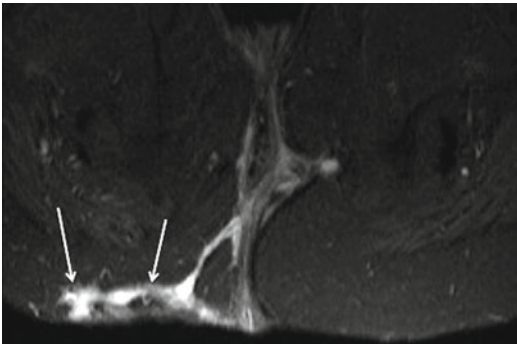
Axial STIR MRI in a patient with extensions (*arrows*) into the right buttock, several cm from the anus
